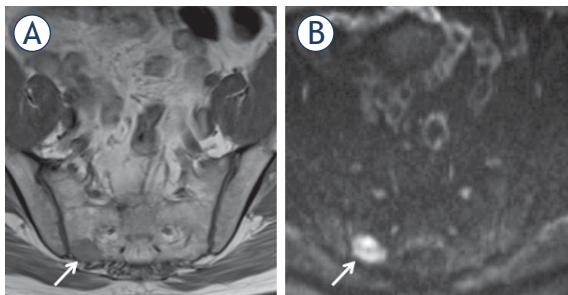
61-yr-old man with PSA = 12.7 ng/ml. Bone metastasis (arrow) in the right sacrum shown as low signal on T1 weighted (T1W) imaging (A); more conspicuous as high signal on diffusion weighted imaging (DWI) (B).
